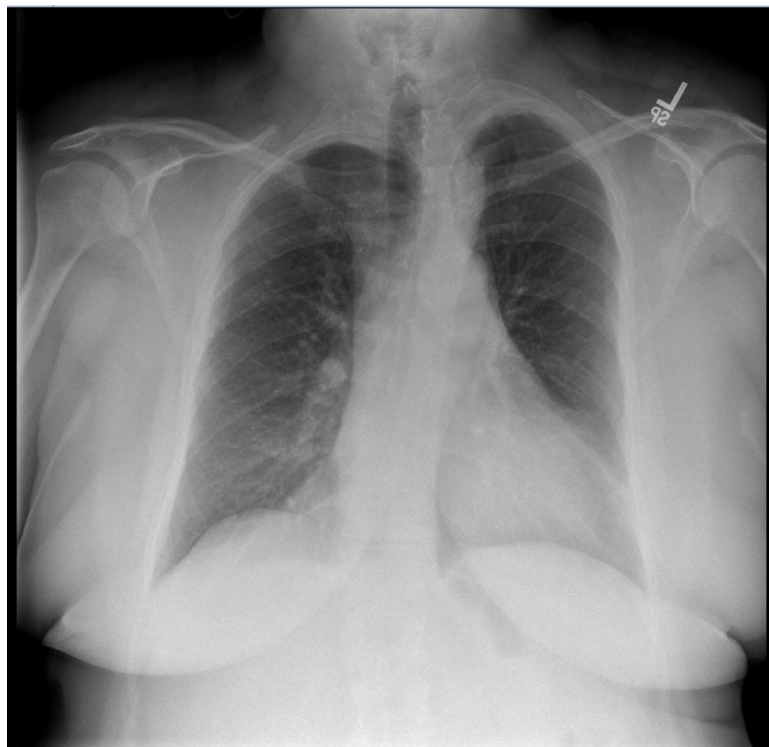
shows normal Chest X-ray.
